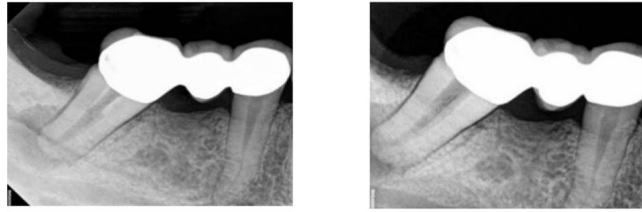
Before the procedure, the radiographic evaluation included (A) a Straight-on and (B) an Angled view, both of which displayed tooth #47 with a sizable pulp chamber housed within a singular conical root
